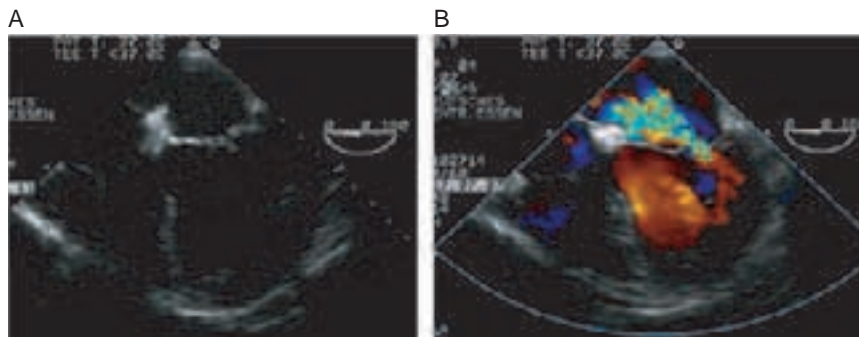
(A) Transoesophageal echocardiography obtained at 0° in a patient with mitral valve prolapse of the posterior leaflet. (B) Colour flow Doppler shows the turbulent jet directed towards the interatrial septum indicating severe mitral regurgitation.
